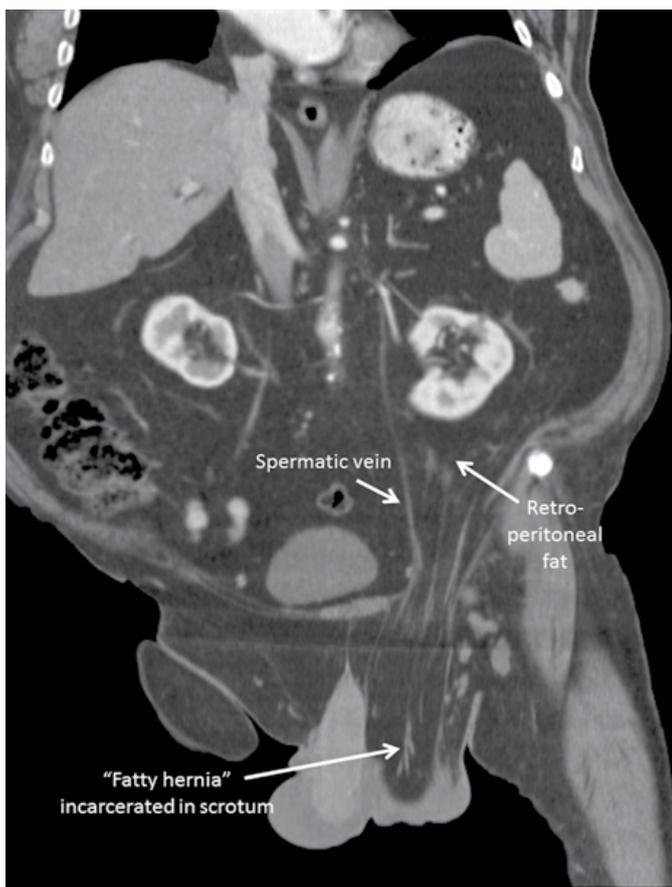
Coronal section of computed tomogram with contrast showing incarcerated 'fatty hernia.'
